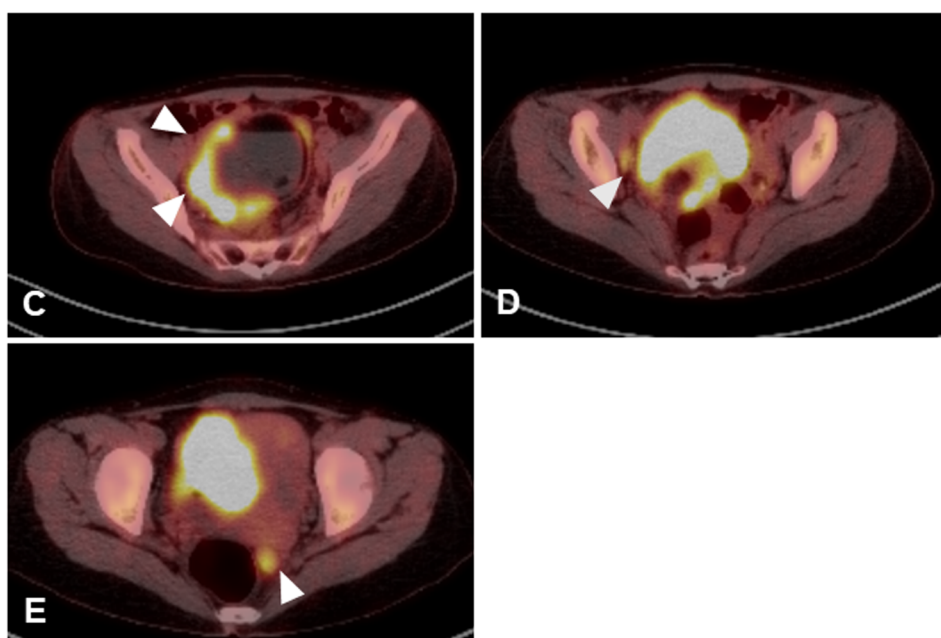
Sagittal T1-weighted (A) and sagittal fat-suppressed contrast-enhanced T1-weighted (B) magnetic resonance images. A large 9.8×6.2 cm mass was observed behind the uterus. The lesion had high signal intensity on the T1-weighted images, which was as low as that of fat on the fat-suppressed contrast-enhanced T1-weighted image (yellow arrowhead). The intensity of the solid part was enhanced on the fat-suppressed contrast-enhanced T1-weighted image compared to that on the T1-weighted image. FDG-PET showed high FDG accumulation in the solid part of the right ovary tumor (white arrowhead) (C), the right external iliac lymph node (D), and a Douglas fossa disseminated lesion (E).
